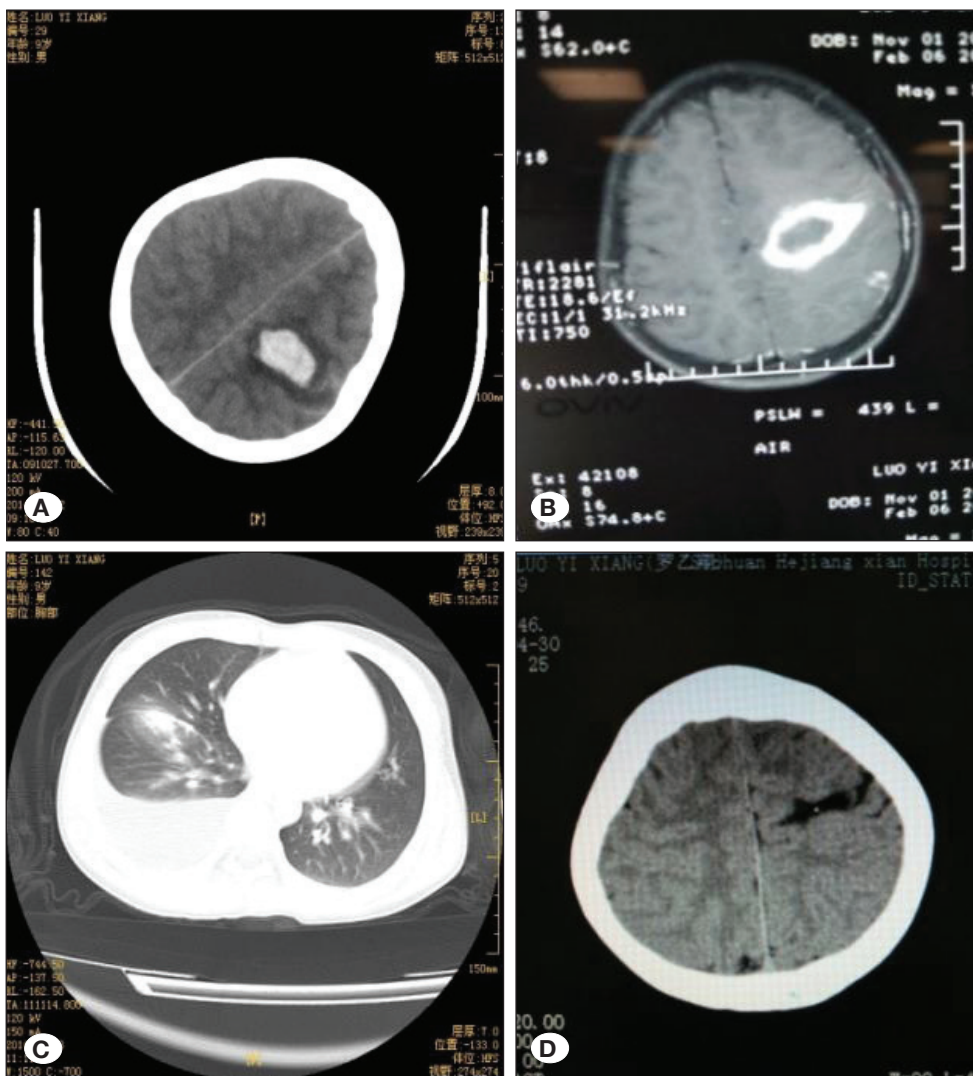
Imaging data of case 1. A) Cerebral CT upon hospitalization showed hemorrhage in the left parietal lobe. B) Cranial MRI upon hospitalization indicated a subacute hematoma in the left parietal lobe. C) Chest CT upon hospitalization showed right pleural effusion. D) Cerebral CT review after 1 year suggested that the hematoma was absorbed, and a softened lesion remained.
